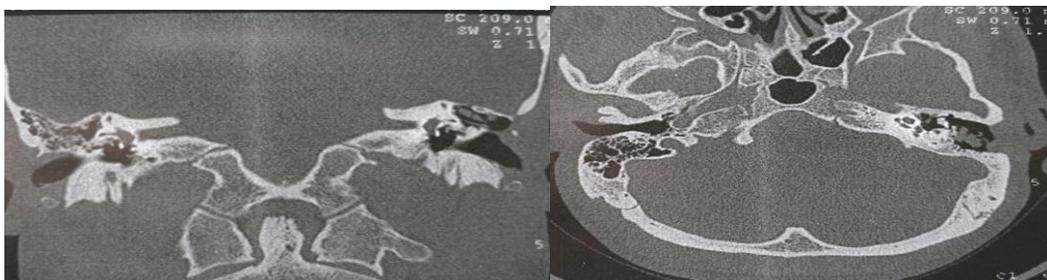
A, B: Axial and Coronal temporal bone CT scan Showing Obliterated mastoid cavity and epitympanic space with near normal EAC concerning shape and contour (cylindrical).
